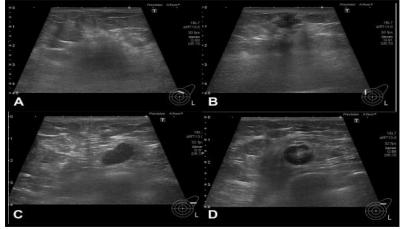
Ultrasound Left Breast – A. Skin thickening with ill defined hypo echoic irregular mass (blue dotted line) in upper outer breast. B. irregular hypo echoic mass in upper medial breast. C. well defined hypo echoic mass with loss of hilum – abnormal lymph node. D. lymph node with thickened cortex. (60).
